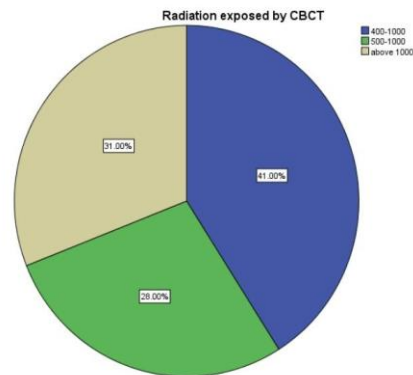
Pie chart shows the response about radiation exposed by CBCT . 41% said radiation exposed by CBCT is 400-100 percent , 28% said radiation exposed by CBCT is 500 -1000 percent and 31% said CBCT exposed radiation above 1000 percent. In that blue colour indicates 400-1000 , green colour indicates 500-1000 and grey colour indicates above 1000.
